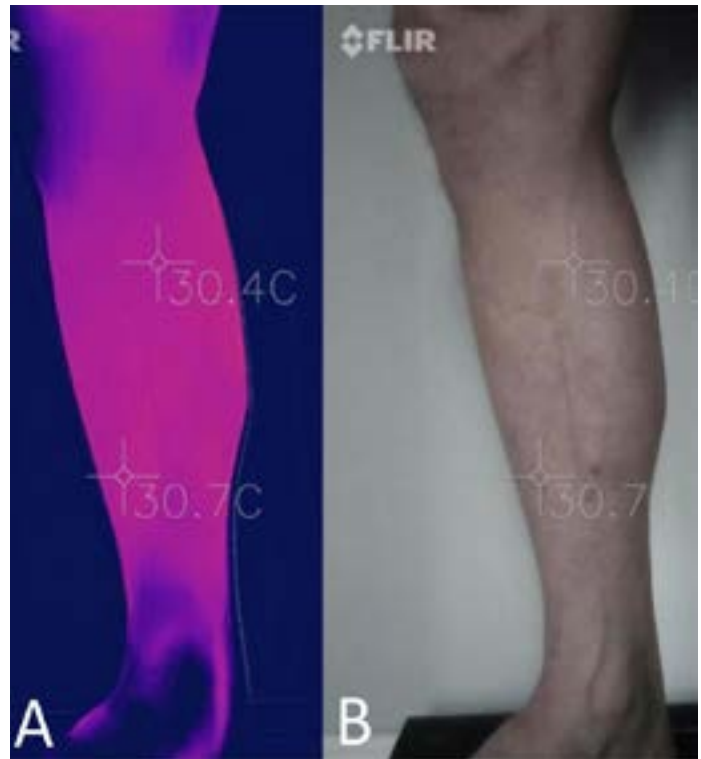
Thermal image (A) and simultaneous optical image (B) of 62-year-old male with obvious superficial veins seen mid-calf. Notice no significant temperature differences on thermal imaging. Ultrasound confirmed that there was no venous incompetence as well.
